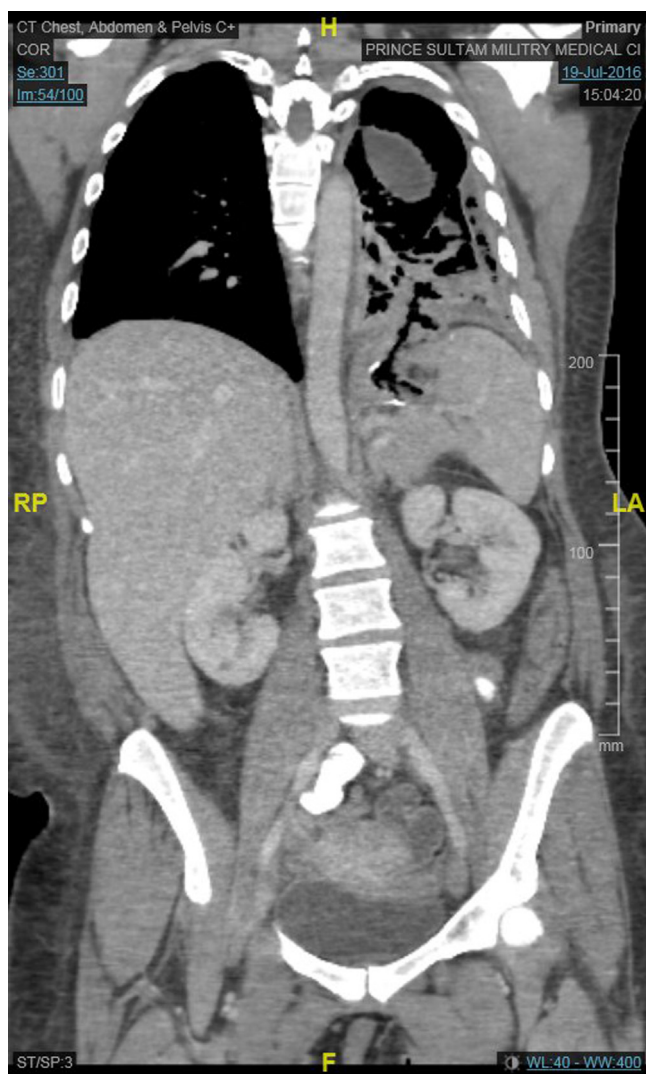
CT scan for chest and abdomen showing air filled tract extending from gastric pouch to left pleural cavity.
